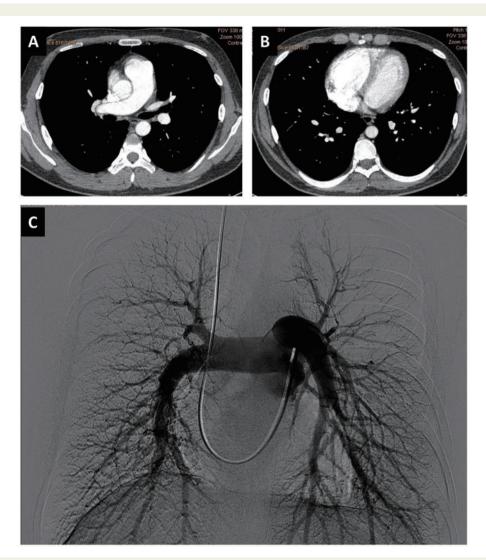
Dilated pulmonary artery (A) and right ventricular enlargement (B) are shown in computed tomography pulmonary angiogram, and pulmonary angiogram showed normal presentation (C).
